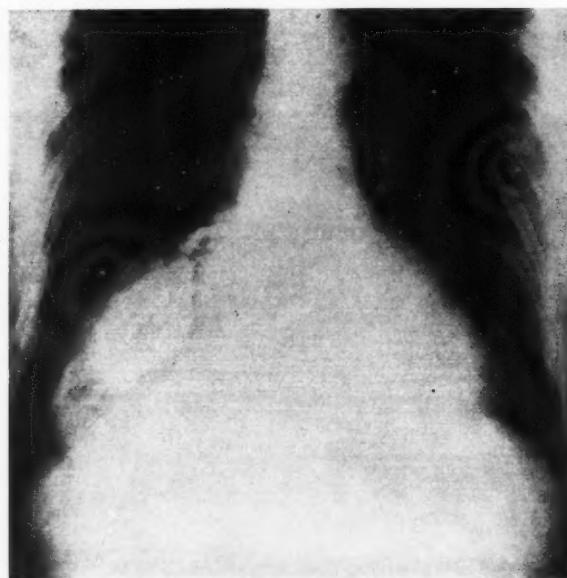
Postero-anterior view, using Potter-Bucky diaphragm, after administration of barium by mouth. The barium is seen in the stomach which is located within the right chest, thus indicating a diaphragmatic hernia. A plain film showed a density in the right lower chest extending outward from the cardiac border.
